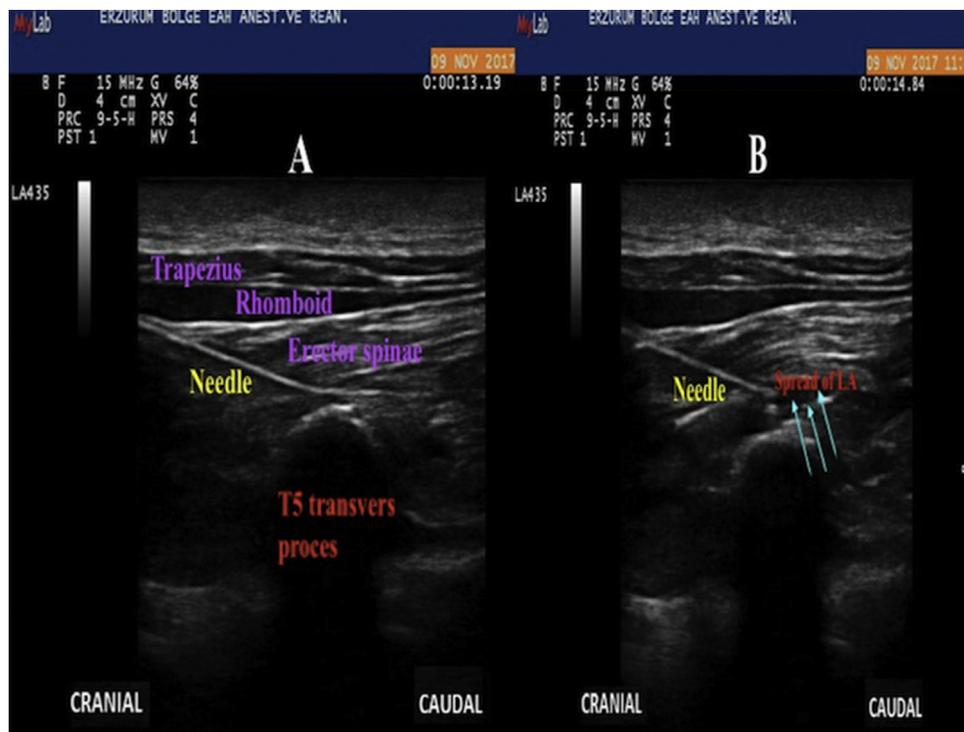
A. Sonographic anatomy of ESP block. B. After local anaesthetics administration.
